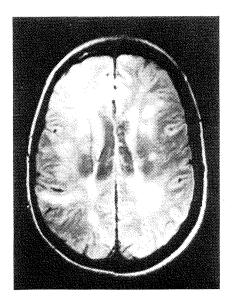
Typical MRI scan of patient afflicted with Multiple Sclerosis. Plaques are demonstrated by the bright areas distributed across the area of the scan.
